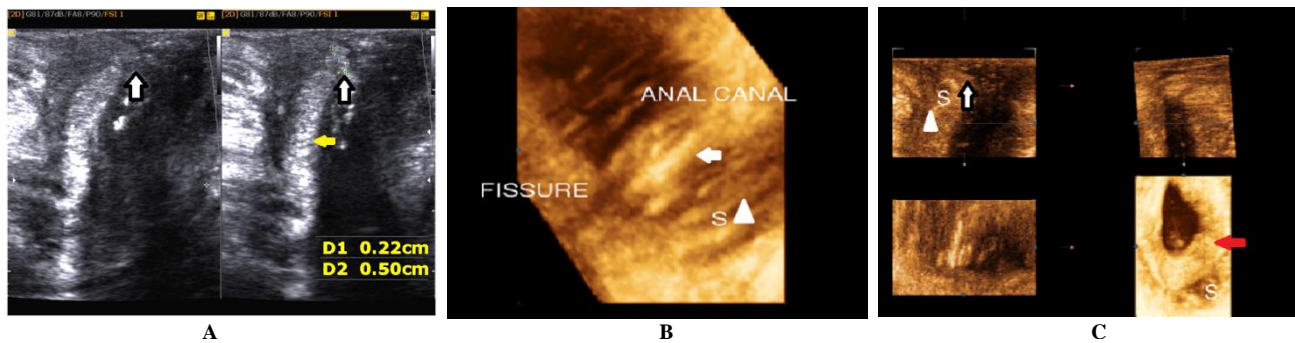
A) 2 dimensional transperineal ultrasound showing gap in the internal anal sphincter at the lower posterior aspect of the anal canal wall (white arrow) and the yellow arrow indicates the internal anal sphincter. B) 3 dimensional surface rendering of the internal anal sphincter narrow defect, an arrow indicates IAS, and the arrowhead indicates an intersphincteric plane sepsis. C) 3 dimensional multiplanar image analysis of the IAS defect (arrow) and the associated intersphincteric plane sepsis (S), the red arrow indicates the internal anal sphincter.
